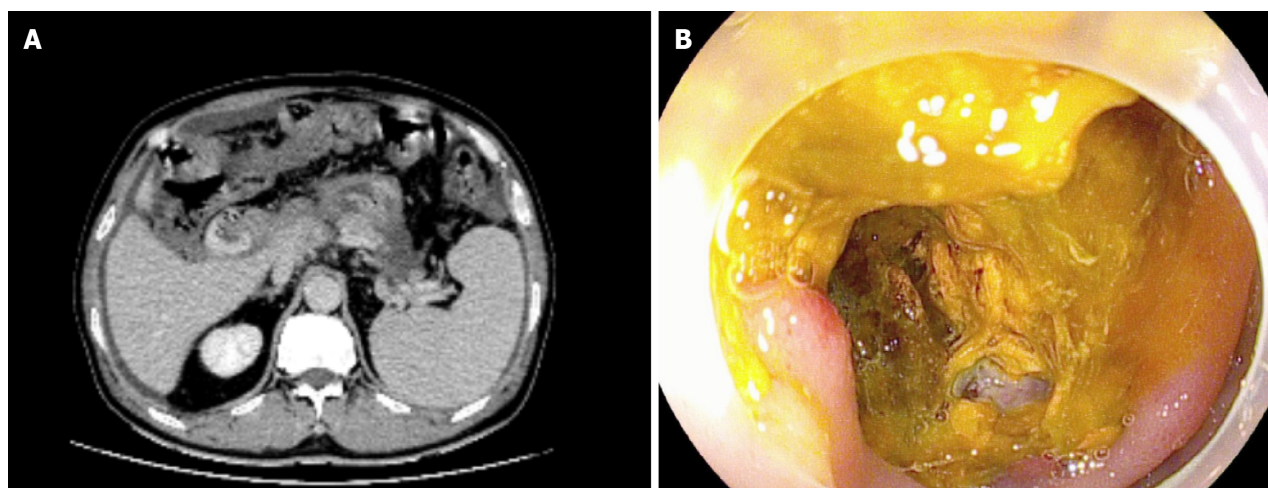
Endoscopic re-examination confirmed no signs of bleeding after endoscopic sclerotherapy (Case 3). A: Follow-up enhanced computed tomography revealed increased soft tissue density in the hepatic hilum, suggesting metastasis; B: Follow-up endoscopy revealed adhesive clumps and exudative ulcers near the choledochojejunostomy site, with no signs of bleeding observed.
